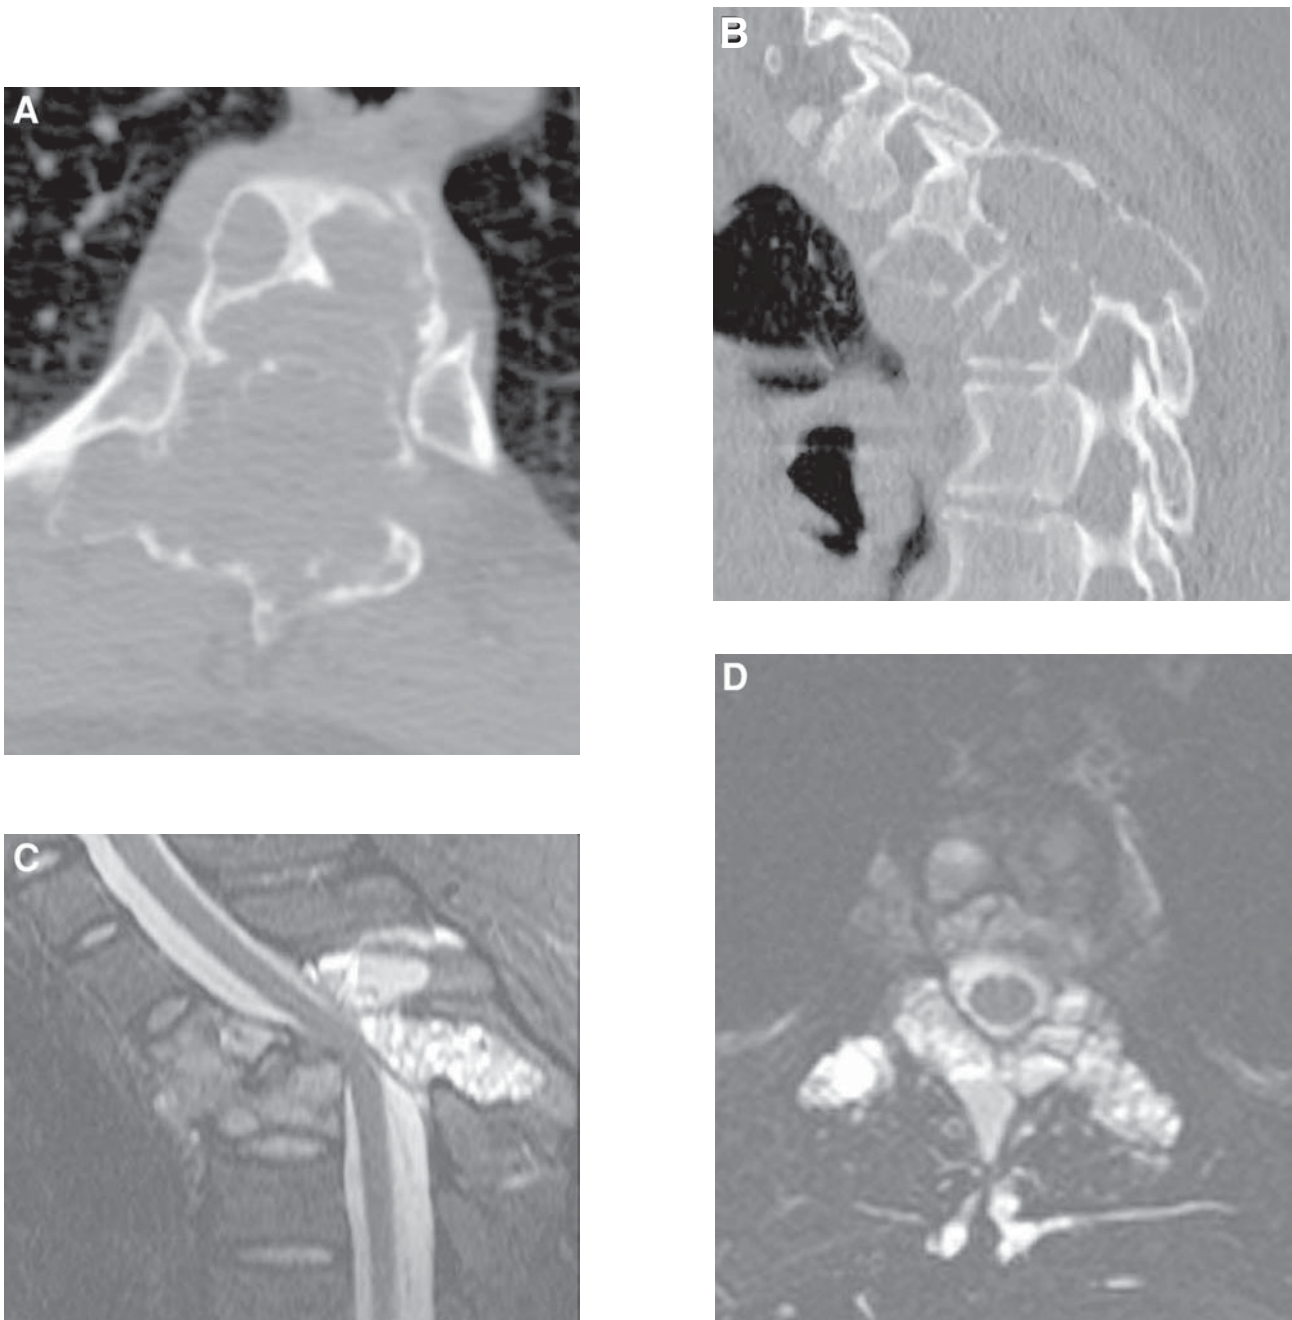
Axial CT (A) and sagittal CT reformation (B) demonstrate expansile, destructive lytic lesions involving both the T2 and T3 vertebral levels. There is involvement of the anterior and posterior elements with vertebral collapse and accompanying kyphosis. Differential considerations would include primary and secondary spinal malignancies (metastatic disease, multiple myeloma, or lymphoma) as well as benign aggressive lesions such as aneurysmal bone cyst (ABC) or osteoblastoma. (C, D) Sagittal and axial STIR demonstrate a characteristic multiloculated, cystic appearance with fluid–fluid levels (indicating hemorrhage). Although not entirely specific, this pattern strongly suggests the diagnosis of ABC, which was confirmed surgically.
